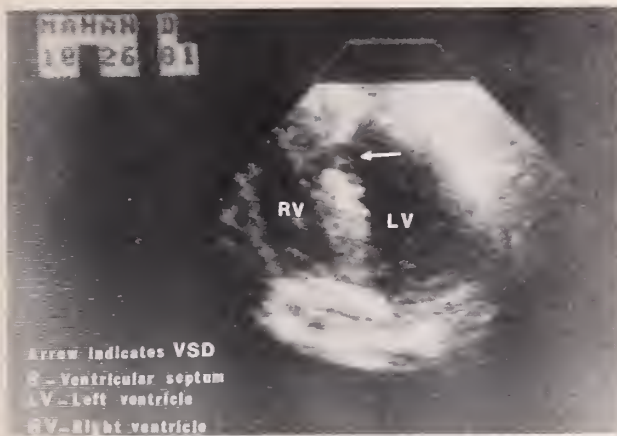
Real time echocardiogram showing VSD shortly after patient's arrival.
